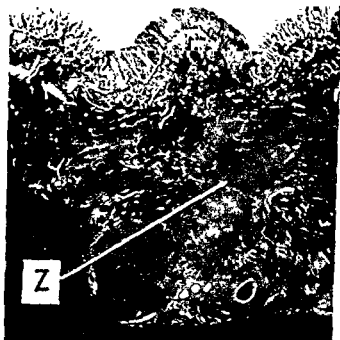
Radiograph of the vessels of the lesser curve 7 mm. distal to the edge of the ulcer shown in Fig. 72. Deep in the submucosa an ischaemic zone is evident (Z). Transverse section across the lesser curve, 400 μ thick. ($\times 3.5$.)
